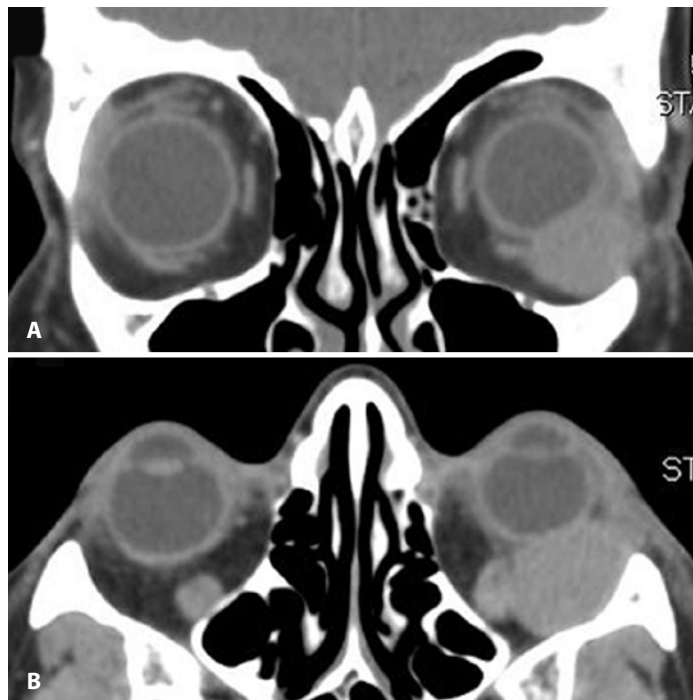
Coronal (A) and axial (B) computed tomography showing a well-defined lesion in the inferior temporal orbit, indenting the globe but without compromising any orbital structure.
